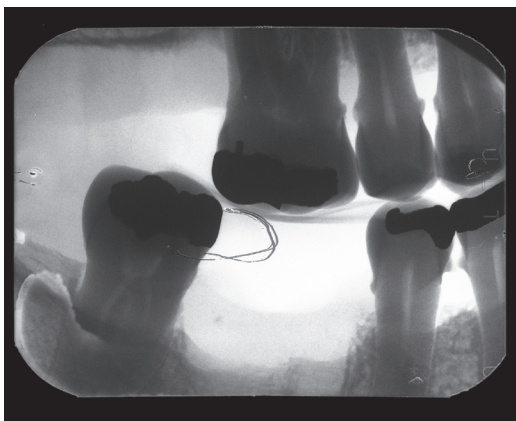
Radiographs can be used to explain treatment plans.
